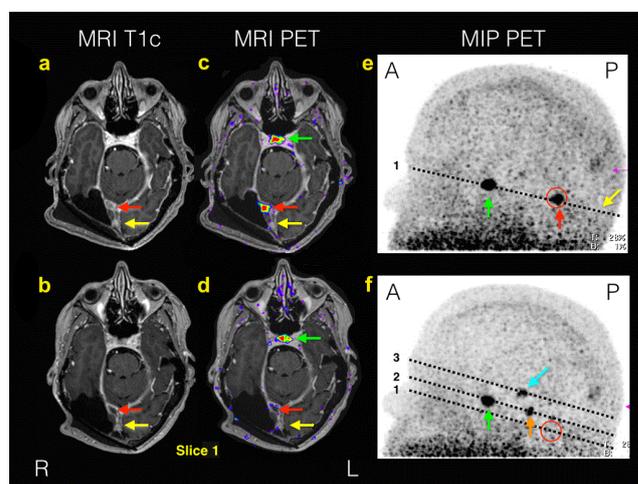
Post-contrast T1-weighted MRI images alone (1a-b, left) and fused with ⁶⁸Ga-DOTATOC PET (1c-d, middle) and maximum image projections (MIP) (1e-f, right) at stereotactic radiotherapy planning (1a, 1c, 1e, top) and after 11 months (1b, 1d, 1f, bottom). The MIP shows all activity in the head in the sagittal plane. The broken lines in the MIP show the relative locations of slices 1-3 and colored arrows the lesions in Figures 1 and 2. The MIP (1e) shows the position of slice 1 with only 2 active foci, the recurrent tumor (red arrow and circle) and physiological ⁶⁸Ga-DOTATOC uptake in the pituitary gland (green arrow), respectively. Initial MRI (1a) indicated a 5 mm in diameter regional tumor recurrence (red arrow) that was confirmed with ⁶⁸Ga-DOTATOC PET (1c). ⁶⁸Ga-DOTATOC PET was used for radiotherapy planning and MRI and PET 11 month later (1b and 1d) showed structural and functional response on MIP (1f, empty red circle). Initially a larger *en plaque* meningioma was suspected on MRI (1a, yellow arrow) but this could not be confirmed on PET (1c) indicating reactive changes and the area was not included in the therapy field. This area was structurally and functionally stationary on follow-up. Orientation: R: Right; L: Left; A: Anterior; P: posterior.
